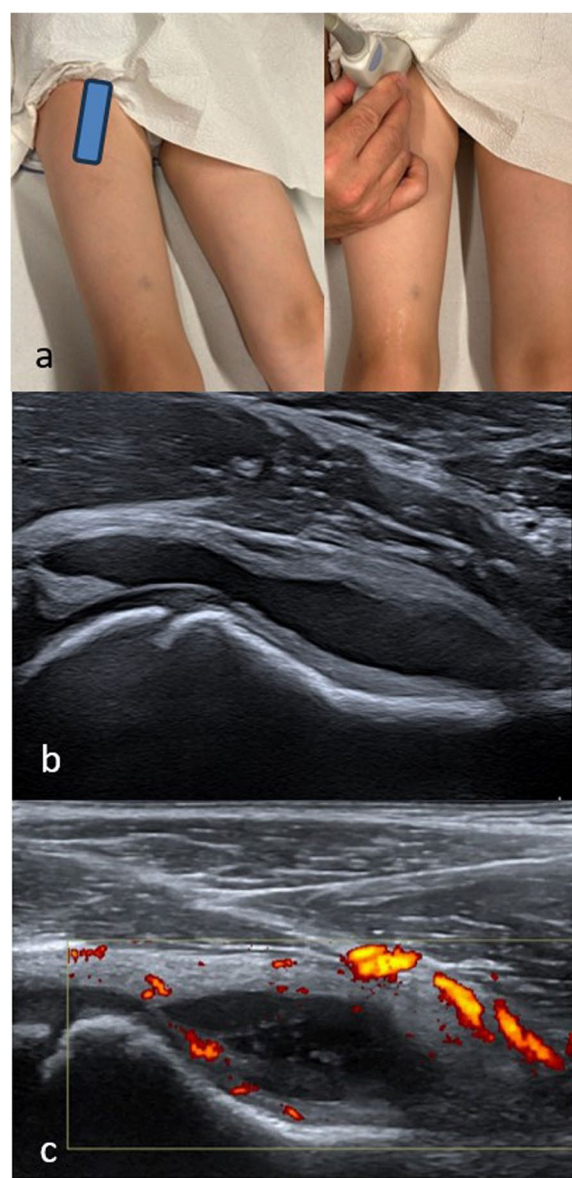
Ultrasound probe placement and example B-Mode and Power-Doppler appearance in the anterior longitudinal view of the hip joint. The optimal placement of the US probe for evaluation of the anterior longitudinal view is shown (a), hip joint effusion with significant distension of the joint capsule (B-Mode Grade 3) is shown (b) and multiple PD signals outside of the joint capsule indicating physiological blood vessels or within the synovial membrane are shown (c)
